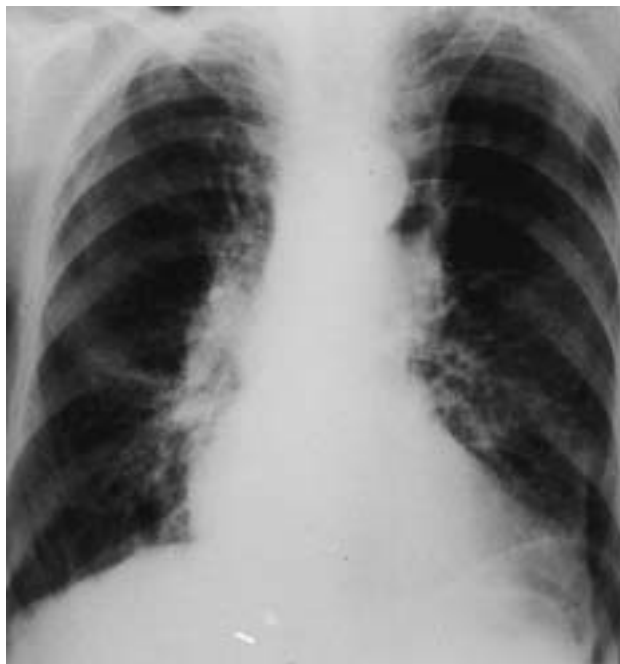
Chest radiograph of patient No. 7 with hilar shadows and proximal streaky opacities.
